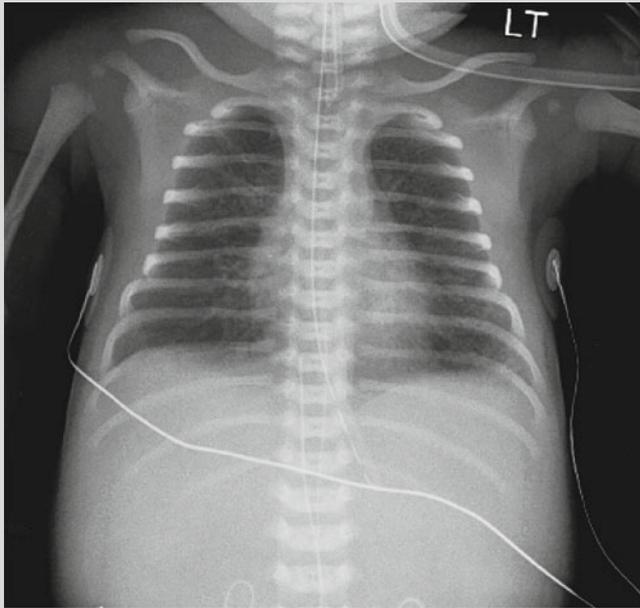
Chest radiograph at 24 h showing hyperinflation, small heart, no air leaks
